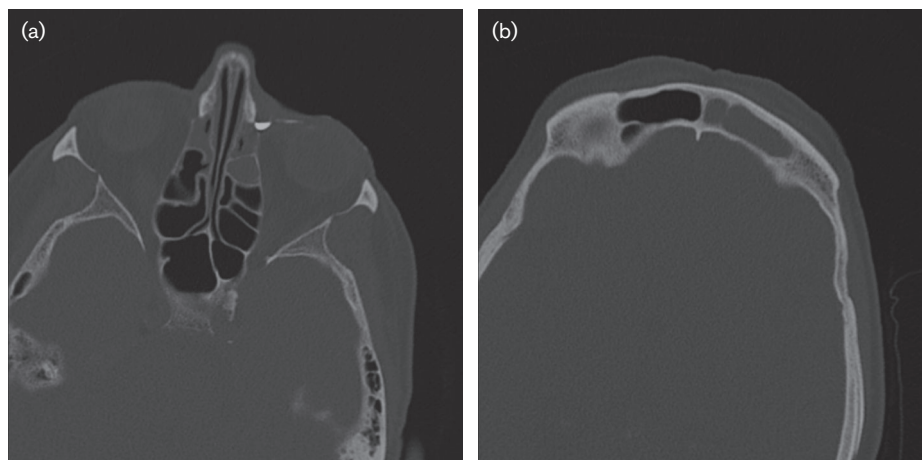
Contrast-enhanced computed tomography of the lacrimal drainage system revealing left-side nasolacrimal duct obstruction (a) and left-side frontal rhinosinusitis (b)
